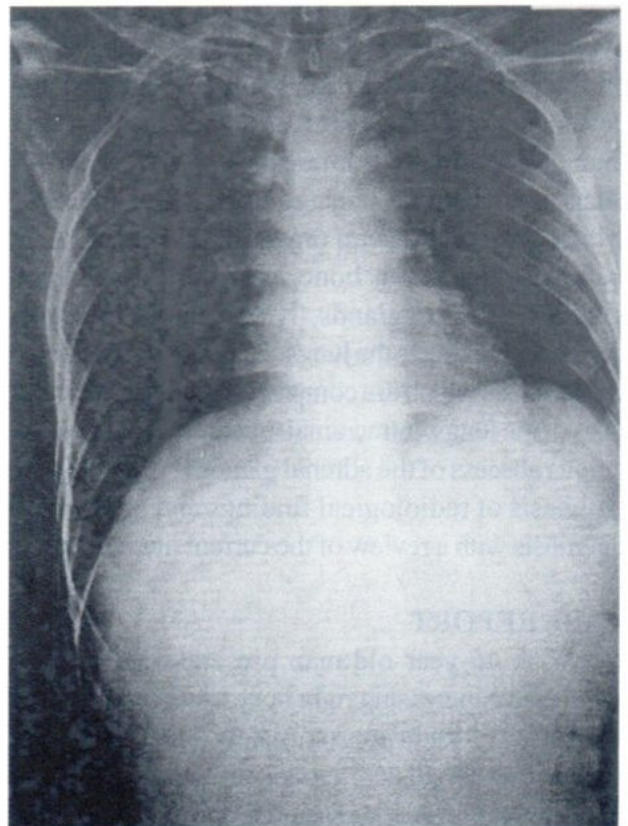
Follow-up chest radiograph after six weeks of antituberculous treatment showed disappearance of pulmonary infiltrations.
